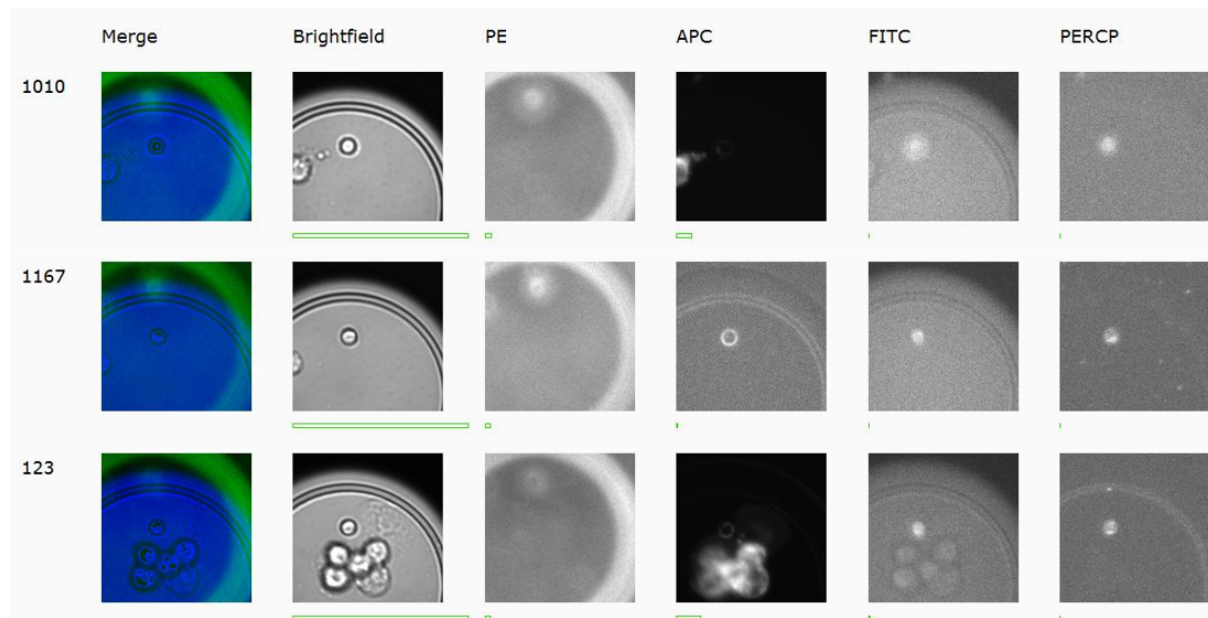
Examples of cells found in the chip. No CTC were identified. Lots of leucocytes were identified. Left the well number. PE: PSMA. APC: CD45. FITC: Calcein. PERCP: EpCAM.
